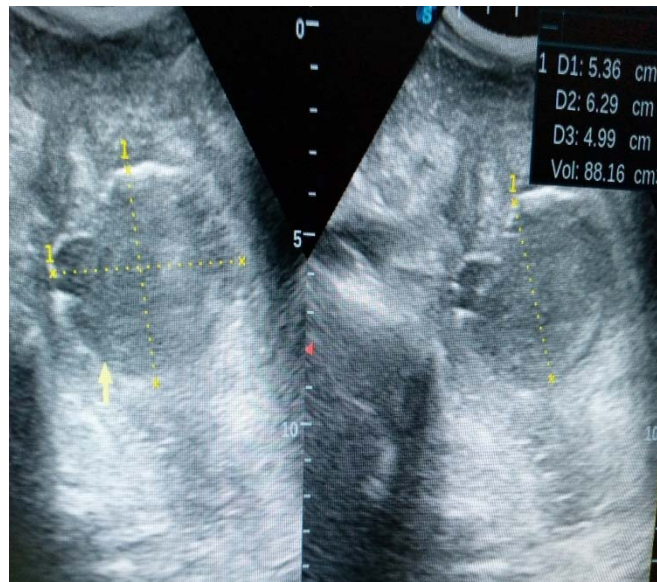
An ultrasonogram of the right iliac fossa region following the use of a 3.5MHz probe transducer showing a near oval area with slight irregularity of the superior walls having a heterogeneous collection with a volume of about 88mls and surrounding hypoechoic fluid; inflammatory and surrounding sentinel loops; focal paralytic ileus. This is the deep seated appendiceal abscess with surrounding focal ileus.
